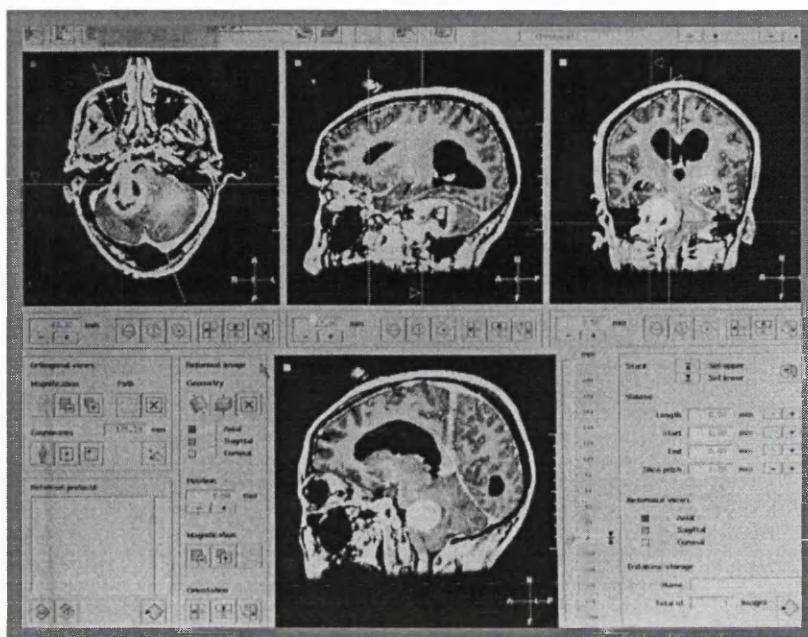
The CT/MR workstation image reformat window. The lesion centre was defined with cross hairs and the three diameters (in the x, y and z axes) measured.
